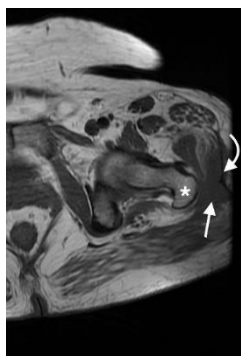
Transverse T1-weighted MRI image. This shows a hypointense abnormality (arrow) between the left greater trochanter (*) and the iliotibial band (curved arrow).
